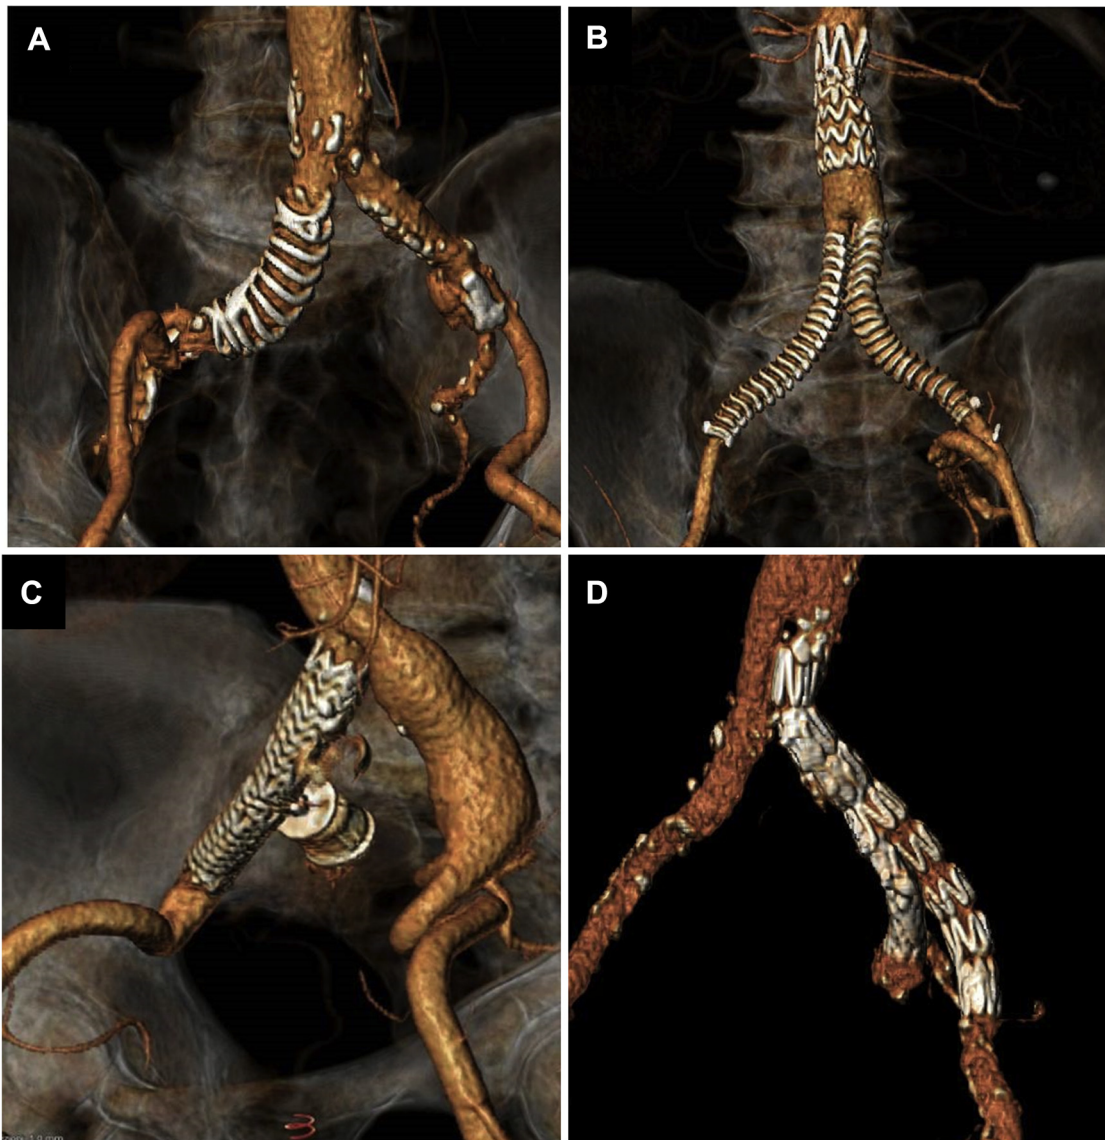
Three-dimensional reconstruction of postoperative CTA. (A) Exclusion of isolated common iliac aneurysm (type I) with iliac endograft. (B) Exclusion of bilateral isolated common iliac aneurysms (type II) with iliac endografts and surgical revascularization of left hypogastric artery (previous deployment of tube aortic
